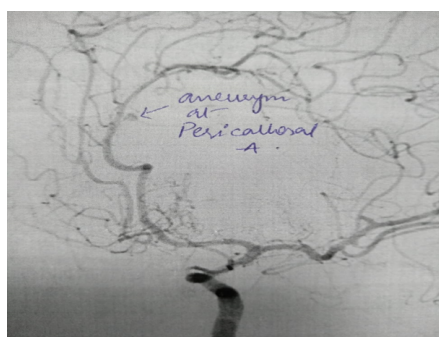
45 years old male patient presented with sudden onset of headache with altered sensorium. Computed tomography show interhemispheric hematoma with intraventricular bleed. DSA was done showing stenosis of bilateral ICA with aneurysm arising from branch of Distal anterior cerebral artery
